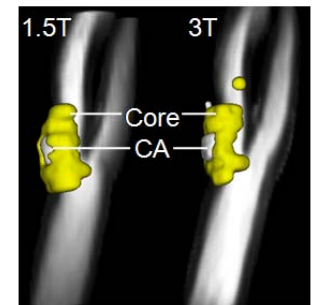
3D renderings of regions and TOF MRA via MRI-PlaqueView (VPDiagnostics, Seattle, WA)
